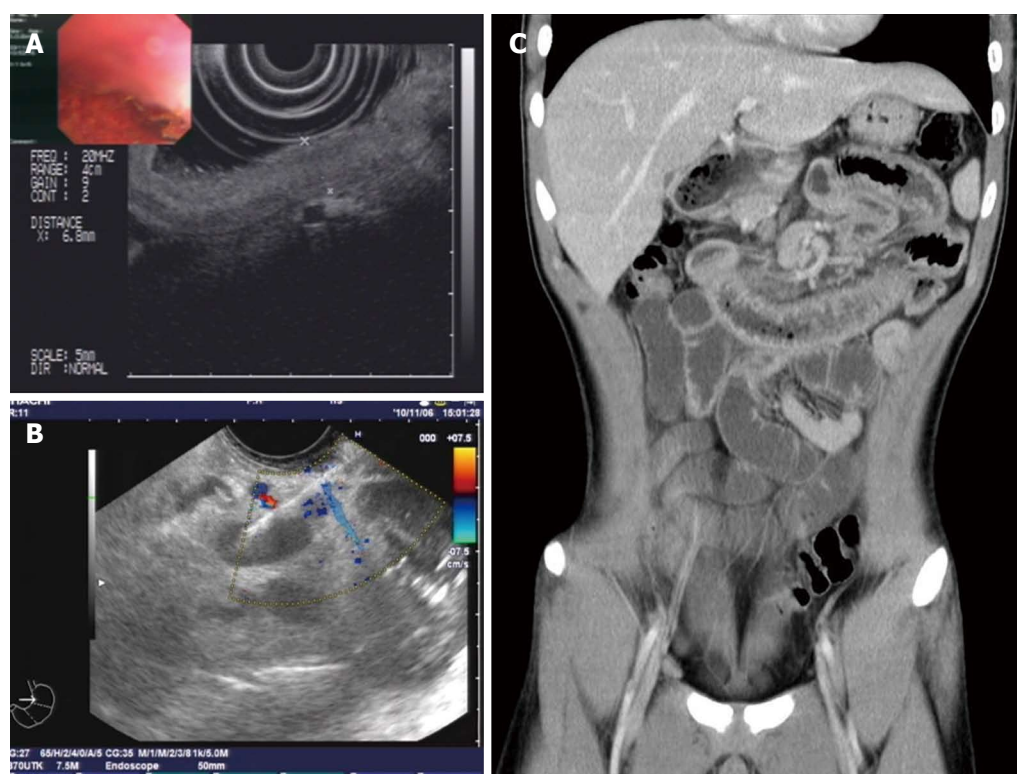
The ultrasound endoscopy and the computed tomography scan indicated the presence of thickened intestinal mucosa and enlarged abdominal lymph nodes. A, B: Ultrasound endoscopy scan images; C: Computed tomography scan images.
